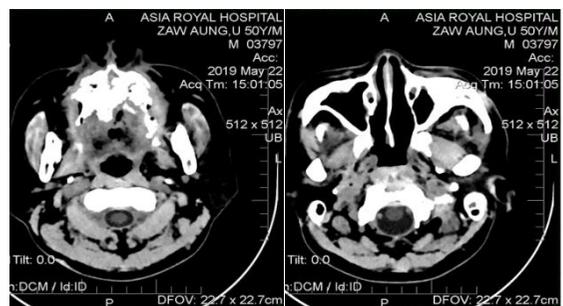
CT scan showed (A) chronic osteomyelitic changes of maxilla, floor of the temporal fossa and base of the skull. Bilateral maxillary sinusitis and left mastoiditis were also noted. (B) Thickened and sclerosed left maxillary sinus lateral wall and left malar prominence
